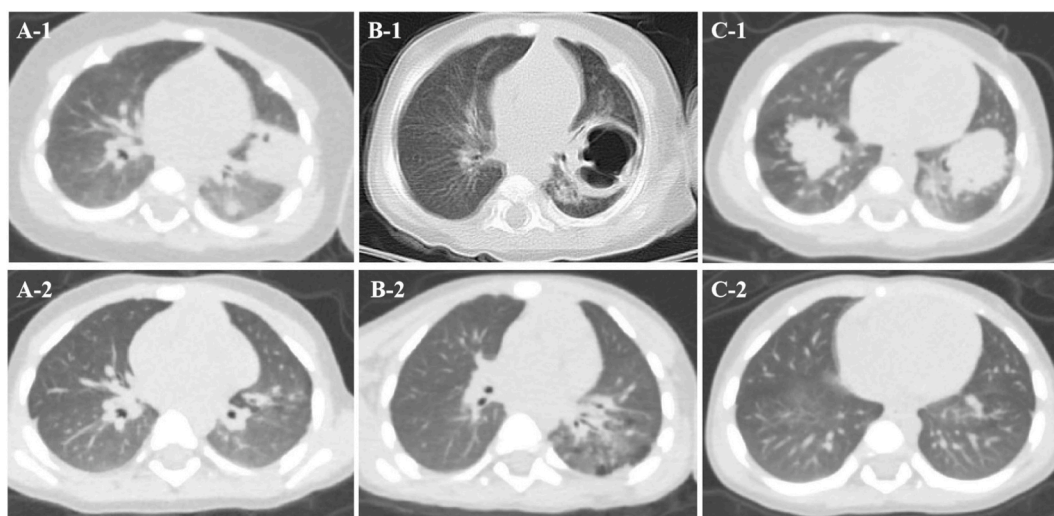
Chest CT scans of fraternal triplets with pulmonary disease at baseline and after 8 months of treatment. (A-1, C-1) Multiple masses and nodules in both middle and lower lung lobes of triplets A and C at baseline. (B-1) Cavities in the left lower lung lobe of triplet B at baseline. (A-2, C-2) Near-complete resolution of pulmonary lesions in triplets A and C after treatment. (B-2) Disappearance of cavities in triplet B after treatment.
